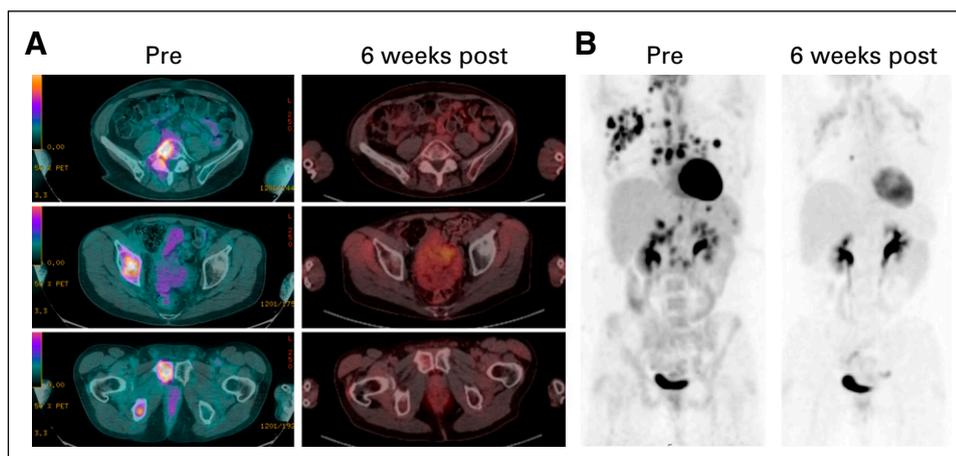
Antitumor effects of CD30-specific chimeric antigen receptor (CAR) T cells (CD30.CAR-T cells). Two patients with relapsed Hodgkin lymphoma: (A) one with several bone lesions in the pelvis and elsewhere, and (B) the other with numerous hypermetabolic lymph nodes, including cervical, right axillary, mediastinal, portacaval, and retroperitoneal before treatment. Six weeks after CD30.CAR-T cell infusion, positron emission tomography-computed tomography scan showed complete responses to therapy (Deauville 2).
